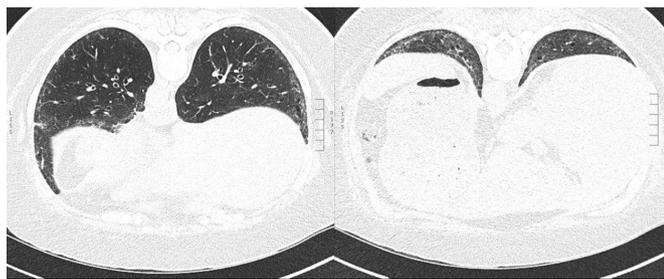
High-resolution CT (HRCT) of the chest, 8 weeks before onset of coronavirus disease 2019 (COVID-19). Ground glass and reticulation as signs of systemic sclerosis (SSc)-associated interstitial lung disease are visible, with an overall lung involvement of <20%.
